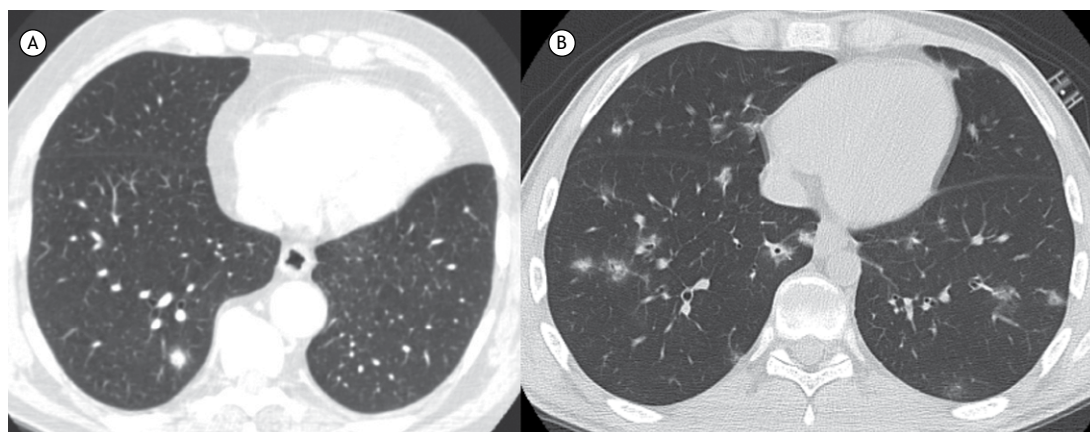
In A, axial CT scan of the chest of an asymptomatic, immunocompetent 54-year-old male patient, showing a right lower lobe pulmonary nodule surrounded by areas of ground-glass opacity (the CT halo sign); the final diagnosis was primary adenocarcinoma. In B, axial CT scan of the chest of an immunosuppressed 19-year-old male patient, showing multiple, randomly distributed pulmonary nodules surrounded by ground-glass opacities (the CT halo sign); the final diagnosis was aspergillosis.
